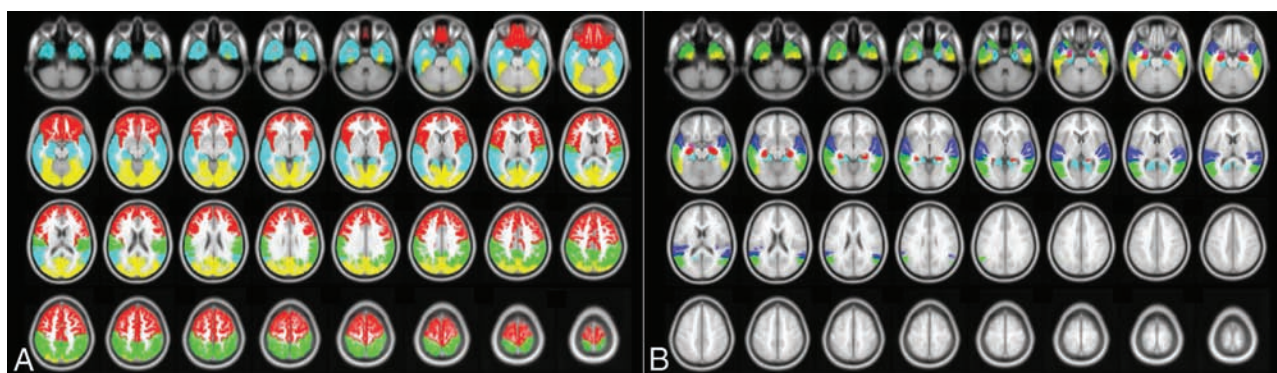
T1-weighted MR images (axial view, A) marking volumes of interest including the frontal, parietal, temporal, occipital cortices, and temporal ROIs (B), including the hippocampus, amygdala, parahippocampus, superior temporal gyrus, middle temporal gyrus, and inferior temporal gyrus by the population-based SPAM. A, Red indicates the frontal cortex; cyan, the temporal cortex; green, the parietal cortex; yellow, the occipital cortex. B, Red indicates the hippocampus; violet, the amygdala; cyan, the parahippocampus; blue, the superior temporal gyrus; green, the middle temporal gyrus; yellow, the inferior temporal gyrus.
